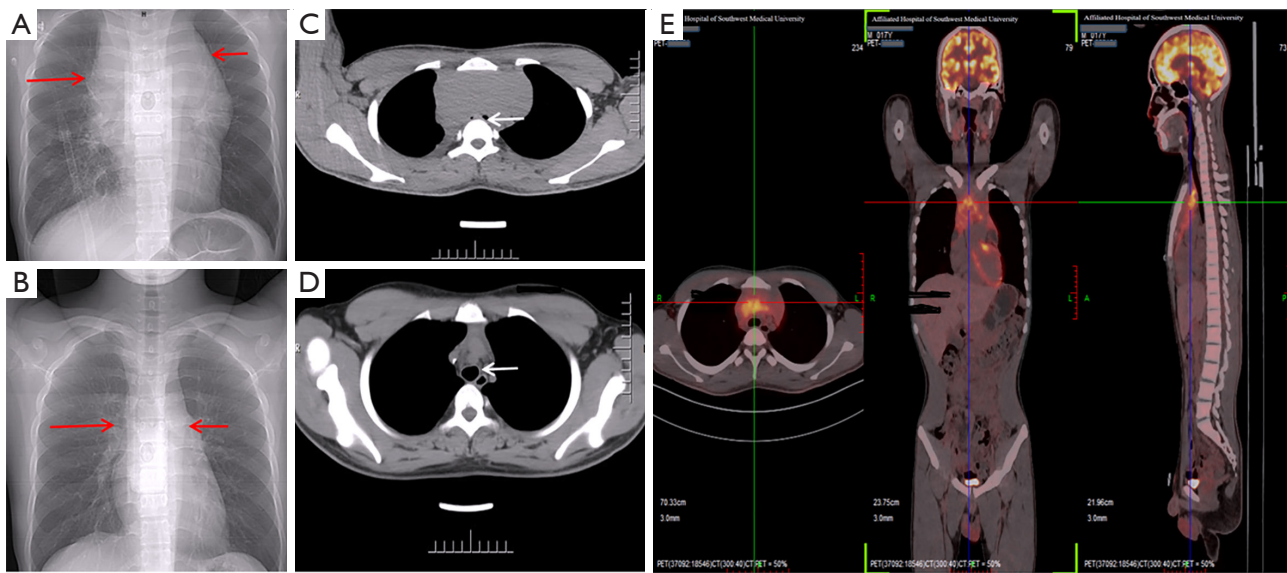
Comparison of imaging data of patients before and after treatment. (A) Prior to treatment, the mediastinal width of the patient's chest radiographs was significantly wider than that of normal individuals, and the red arrows on both sides of the mediastinum indicated the development of mediastinal masses. (B) X-ray examination of the patient's chest after treatment revealed that the width of the mediastinum had decreased significantly compared to that before treatment, and the red arrows on both sides of the mediastinum indicated the development of mediastinal masses. (C) Prior to treatment, a plain CT scan of the patient's chest revealed a huge space-occupying lesion in the anterior mediastinum, with a maximum cross section of about 15.0 cm × 20.0 cm. The mass severely compressed the main bronchus above the bifurcation of the left and right main bronchus, and the narrowest part of the main bronchus was only about 2 mm × 3 mm (indicated by the white arrow). (D) After treatment, plain CT scan of the patient's chest showed that the mediastinal mass had been greatly reduced, and the diameter of the main bronchus originally oppressed by the mass had almost returned to normal level (indicated by the white arrow). (E) On the third day after treatment, the patient's PET-CT examination showed that the mediastinal mass had been significantly reduced, with a maximum cross section of 3.8 cm × 5.3 cm, and the inner diameter of the main bronchus under pressure had almost returned to normal. PET, positron emission tomography; CT, computed tomography.
